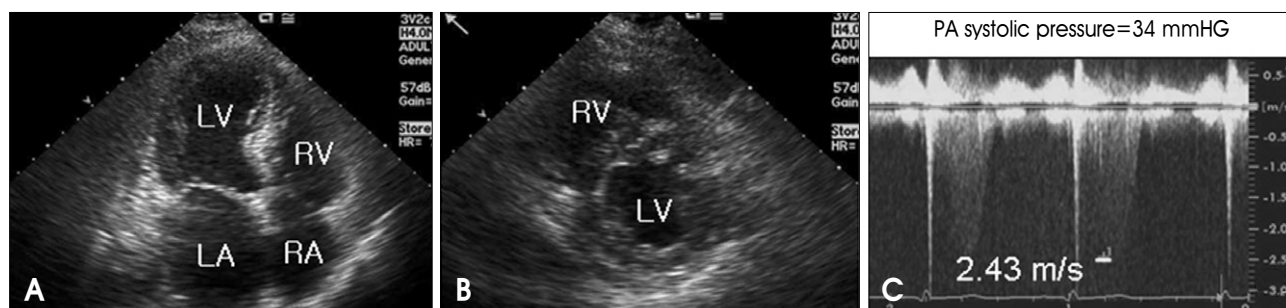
Follow-up transthoracic echocardiography for second episode of severe dyspnea. On hospital day 8, RV overloading is much improved with a decreased PA systolic pressure of 34 mmHg (C). In contrast, LV and LA are enlarged. LV has a balloon-like akinetic apex and hyperkinetic basal walls (A, B). She was diagnosed with apical ballooning syndrome. RV: right ventricle, RA: right atrium, LV: left ventricle, LA: left atrium, PA: pulmonary artery.
